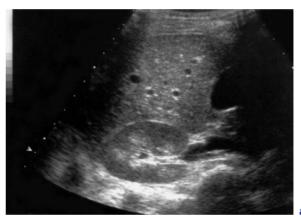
Renal sonography in sickle cell disease. a Increased echogenicity of the medulla with consecutively inverted corticomedullary differentiation. In the absence of hypercalciuria, this pattern is typical for sickle cell nephropathy. b Amplitude-coded color Doppler sonography of the right kidney (*cross section*) shows a segmental parenchymal area without colour signals (*arrow*), consistent with a renal infarction in sickle cell disease
